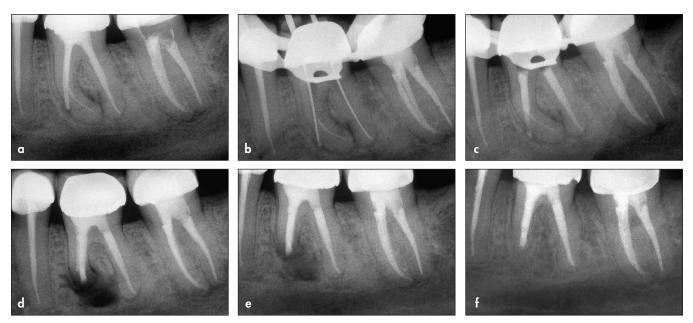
(a) Mandibular left first molar in a symptomatic 32-year-old man. Note the presence of a separated file at the mesial root apex and concomitant transportation and perforation of the mesial root canal during previous treatment. (b) Identification of the perforation site. (c) Canal obturation with gray MTA. (d) Surgical resection of the mesial roots, removal of the separated file, and MTA retrofill. (e) Nine-month radiographic review. (f) Three-year recall radiograph showing complete remineralization of the osteotomy site.
